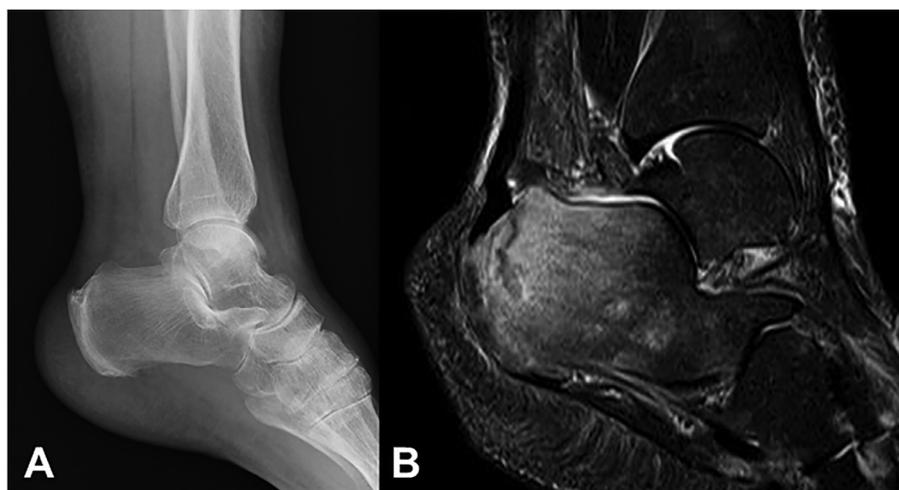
Type 1 calcaneal insufficiency fracture. (A) Lateral plain radiograph showing no fracture line. (B) Sagittal views on fat-suppression T2-weighted images. The fracture line, i.e., the low-intensity line surrounded by bone marrow oedema, was irregular from the insertion of the Achilles tendon to the bottom, perpendicular to the posterior calcaneal trabecular line.
